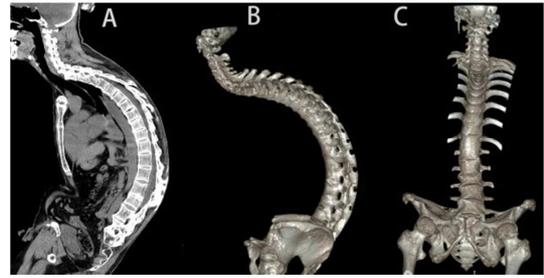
Spinal CT before operation: Scoliosis, Kyphosis; Ankylosing spondylitis.
